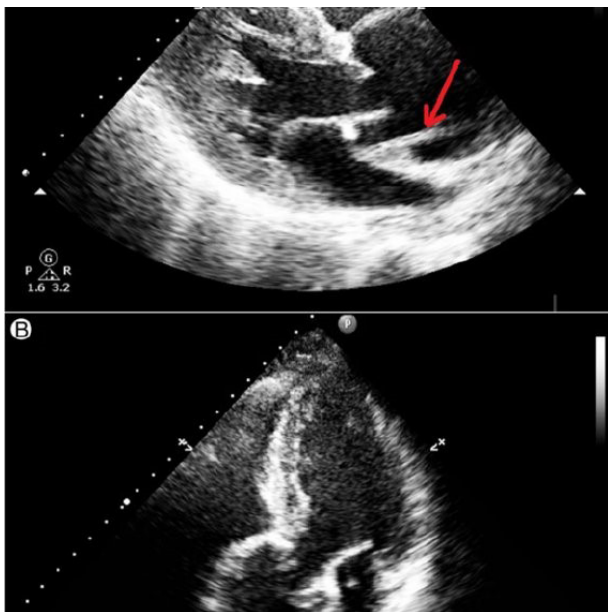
Transthoracic echocardiogram images of aortic dissection.
